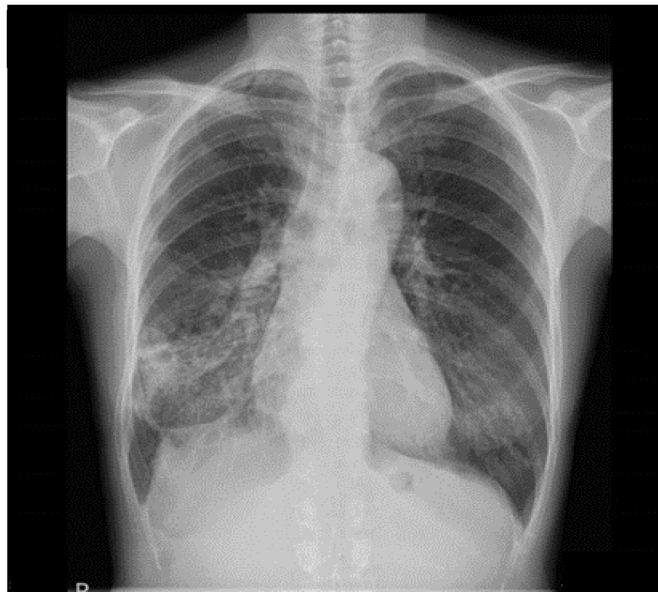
The pre-treatment chest radiograph shows infiltrations in both lower lung fields.
